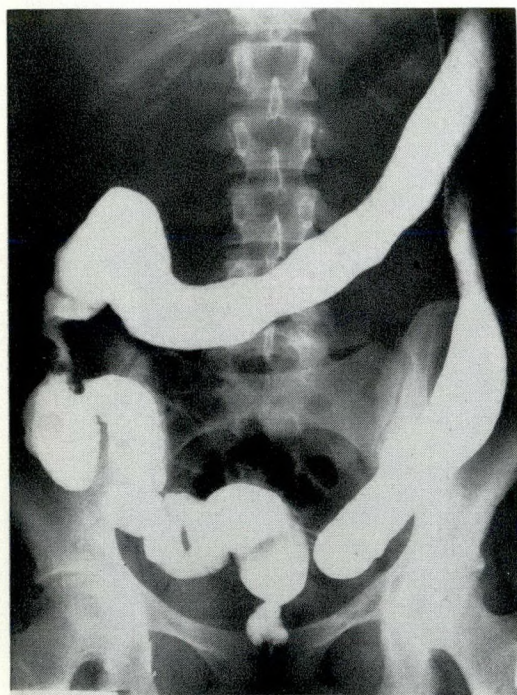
(Case 3)—Radiograph of a carcinoma of the ascending colon in a patient aged 22 years with colitis for 20 years.
